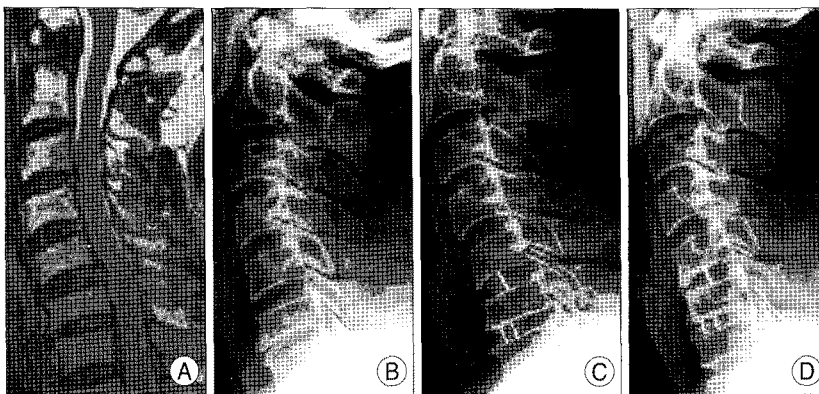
A : Pre-operative magnetic resonance (MR) image shows disc herniation at C5-6 and C6-7. B : Pre-operative simple lateral radiograph. C : Postoperative simple lateral radiograph immediately shows ACDF, C5-6 & C6-7 with Solis cage. D : Simple lateral radiograph at two years postoperative shows fusion state without subsidence and adjacent level degeneration.
